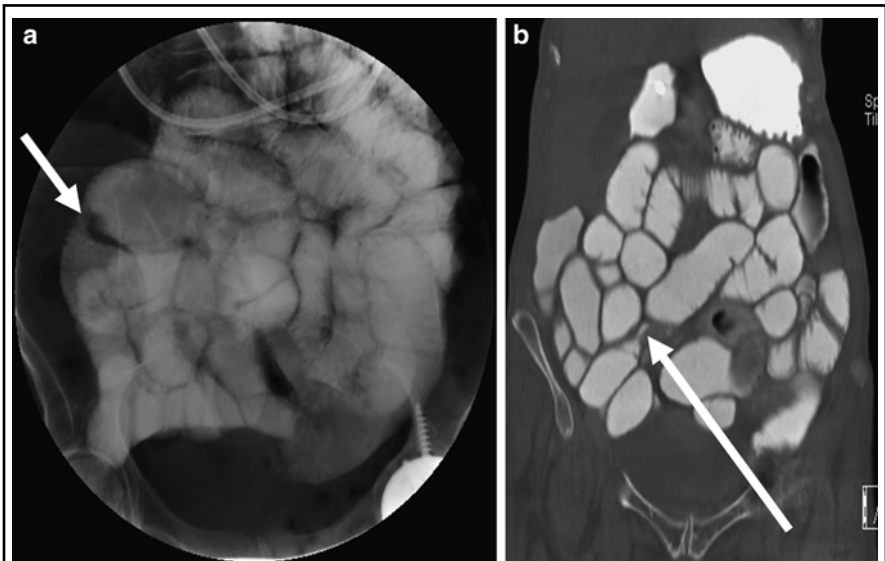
CONVENTIONAL VERSUS CT ENTEROCLYSIS
